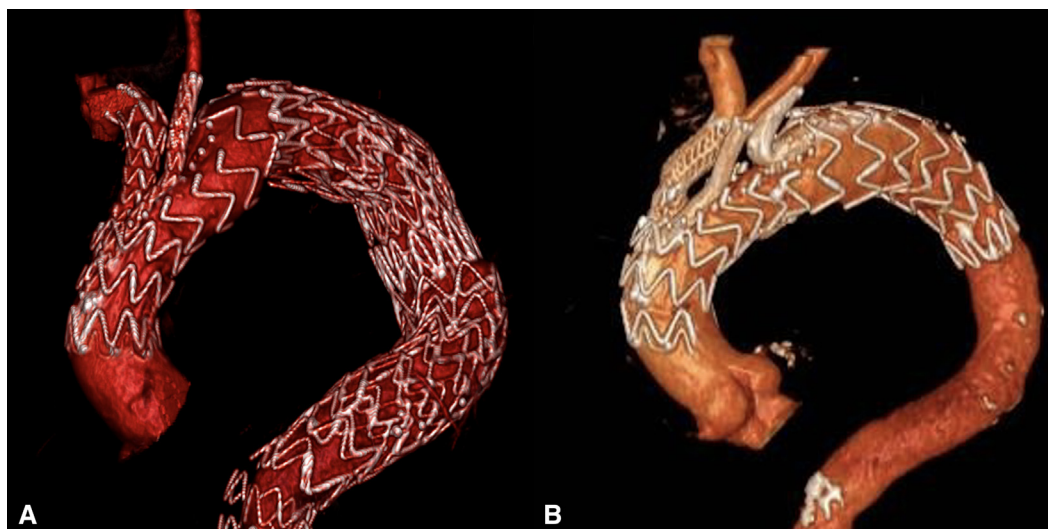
Results of arch branched endovascular aortic repair at the postoperative computed tomography scan. Double-branch with a left carotid-subclavian bypass (A) and triple-branched prosthesis (B).
